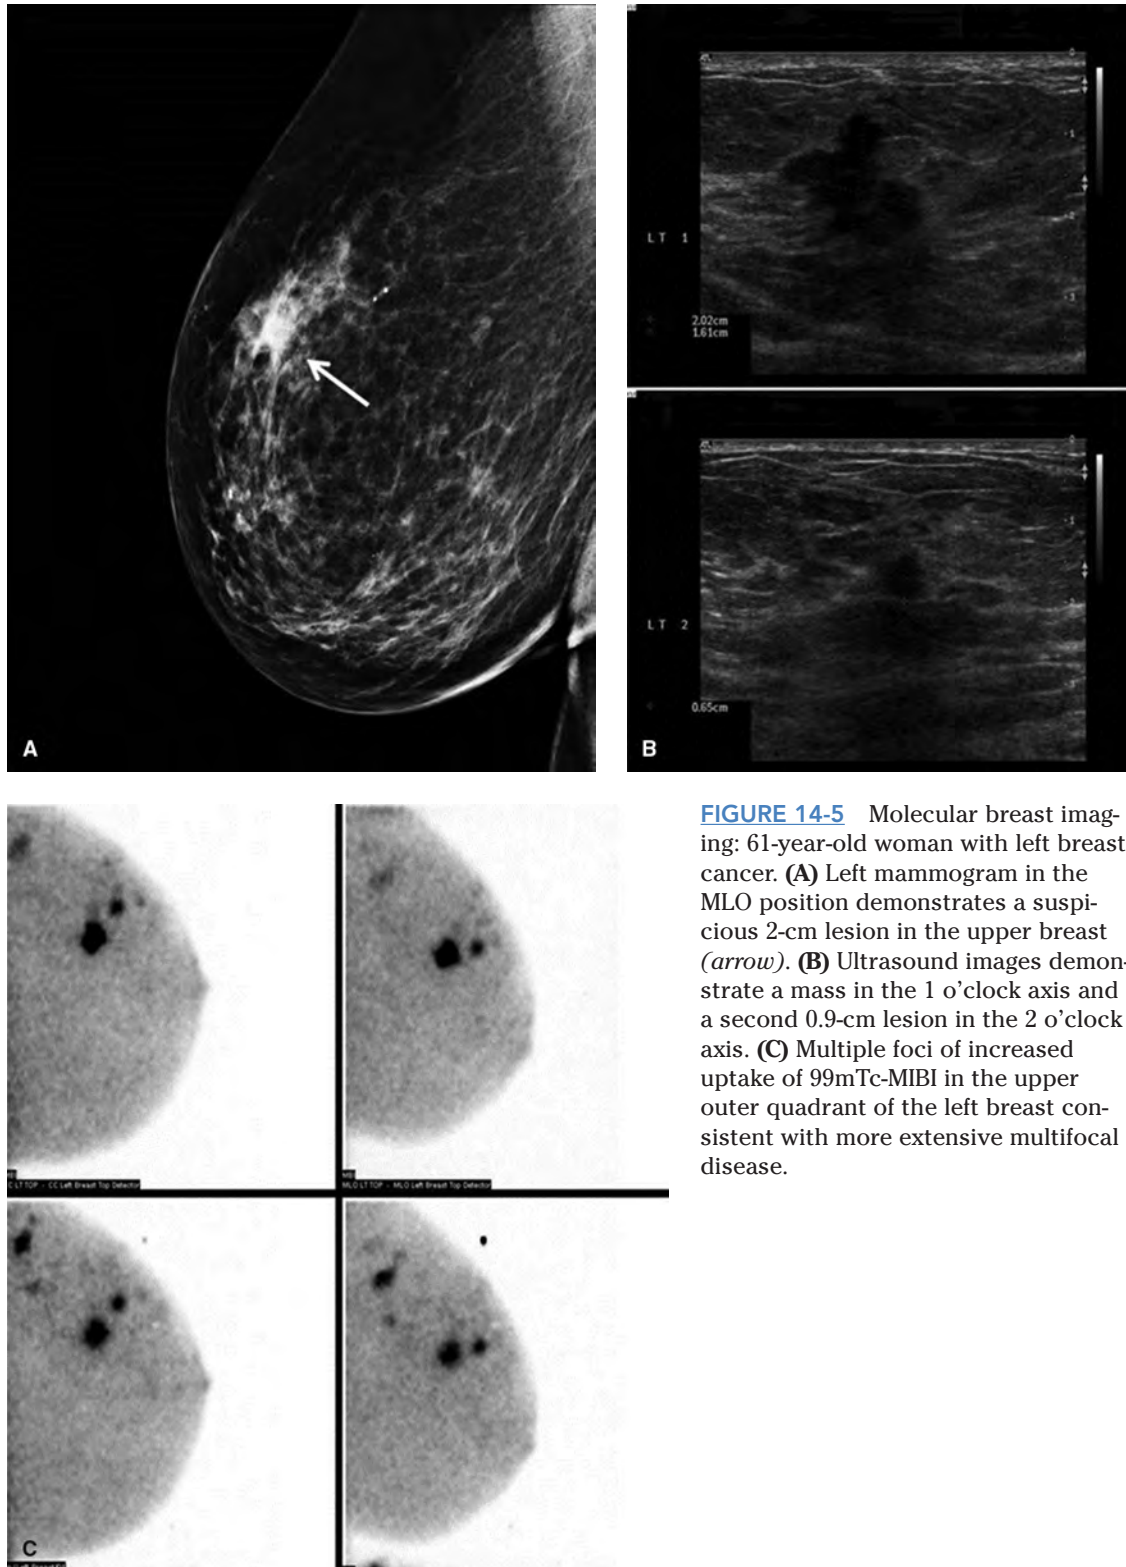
Molecular breast imaging: 61-year-old woman with left breast cancer. (A) Left mammogram in the MLO position demonstrates a suspicious 2-cm lesion in the upper breast (*arrow*). (B) Ultrasound images demonstrate a mass in the 1 o'clock axis and a second 0.9-cm lesion in the 2 o'clock axis. (C) Multiple foci of increased uptake of ^{99m}Tc -MIBI in the upper outer quadrant of the left breast consistent with more extensive multifocal disease.
